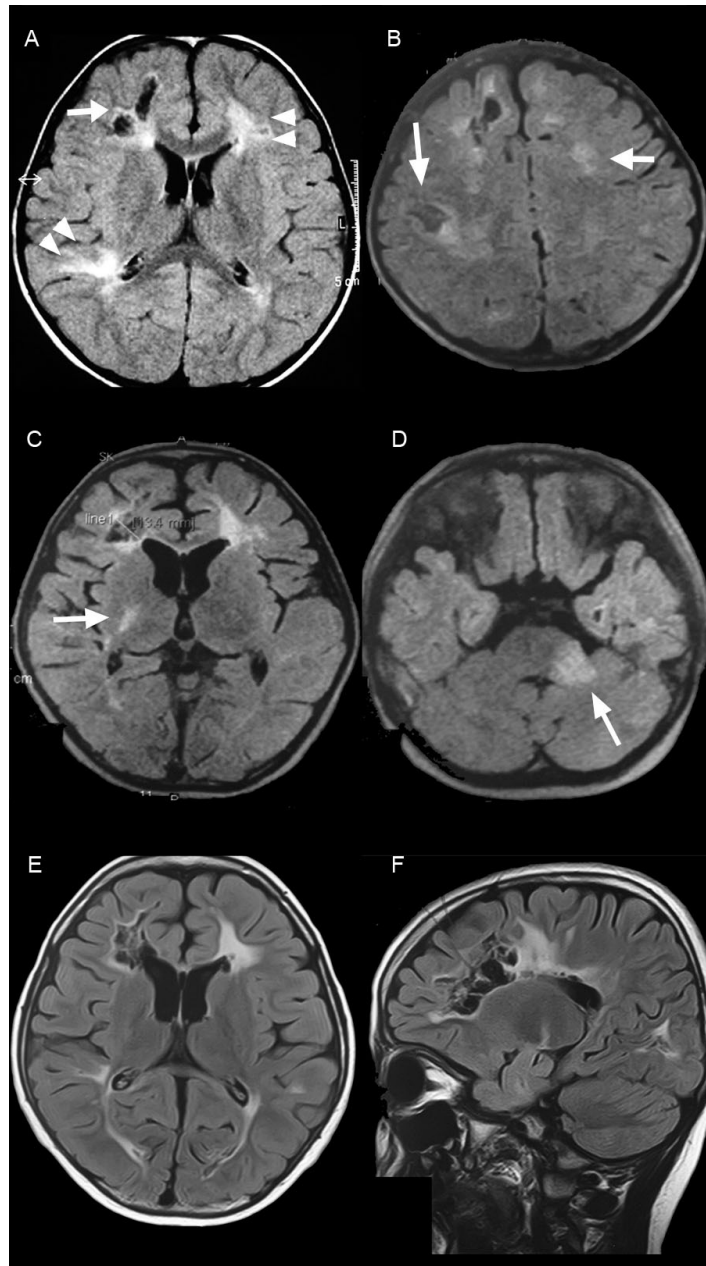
Serial MRI brain images from a 6 year old boy with relapsing-remitting multiple sclerosis. (A). First presentation with optic neuritis, but no symptoms referable to the central nervous system. Axial T2 FLAIR brain image showing two hypointense “black holes” in the right frontal region (white arrow) and hyperintense demyelinating lesions (arrowheads) over the left frontal and bilateral parietal-occipital periventricular region. (B). Surveillance MRI study at 3 months. He was asymptomatic at this time. Axial T2 FLAIR brain reveals multiple new white matter lesions in the right parietal lobe and left centrum semiovale (white arrows). (C), (D). Serial MRI axial T2 FLAIR brain scans at different time points in the 3 years of frequent relapses showing new symptomatic lesions in the right internal capsule (clinical left hemiparesis) (C) and left cerebral peduncle (clinical right hemiparesis) (D). (E), (F). Surveillance MRI during a quiescent, asymptomatic phase following pulsed cyclophosphamide therapy. Axial and sagittal T2 weighted brain images showing accumulation in white matter injury over time – extensive hyperintense white matter lesions with larger areas of axonal loss (“black holes”).
